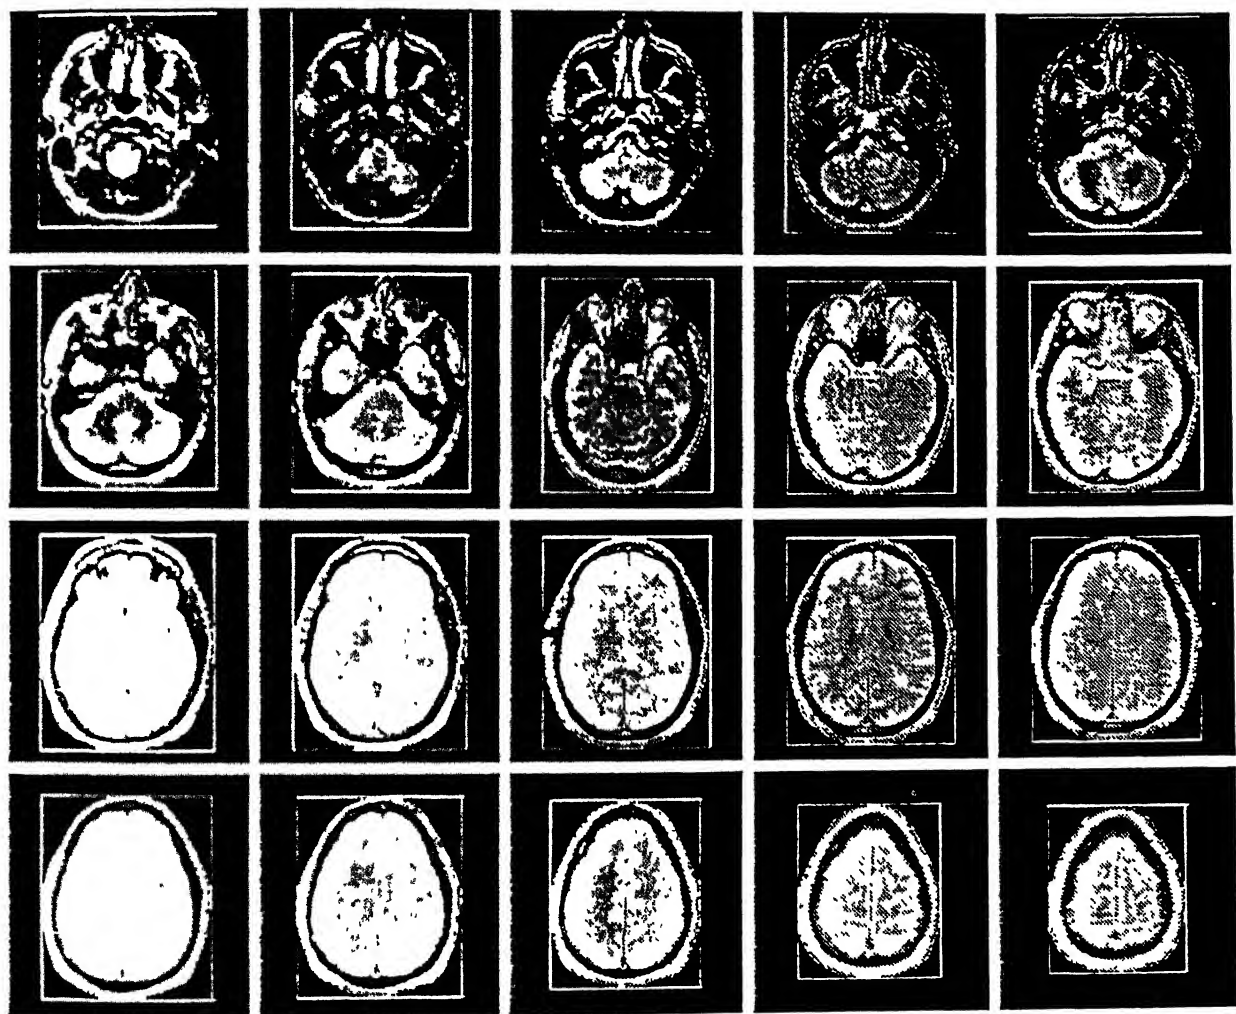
The Head Mask as well as the Head Bounding Box for MRI Data Set 3 overlaid on the PD-weighted scan
